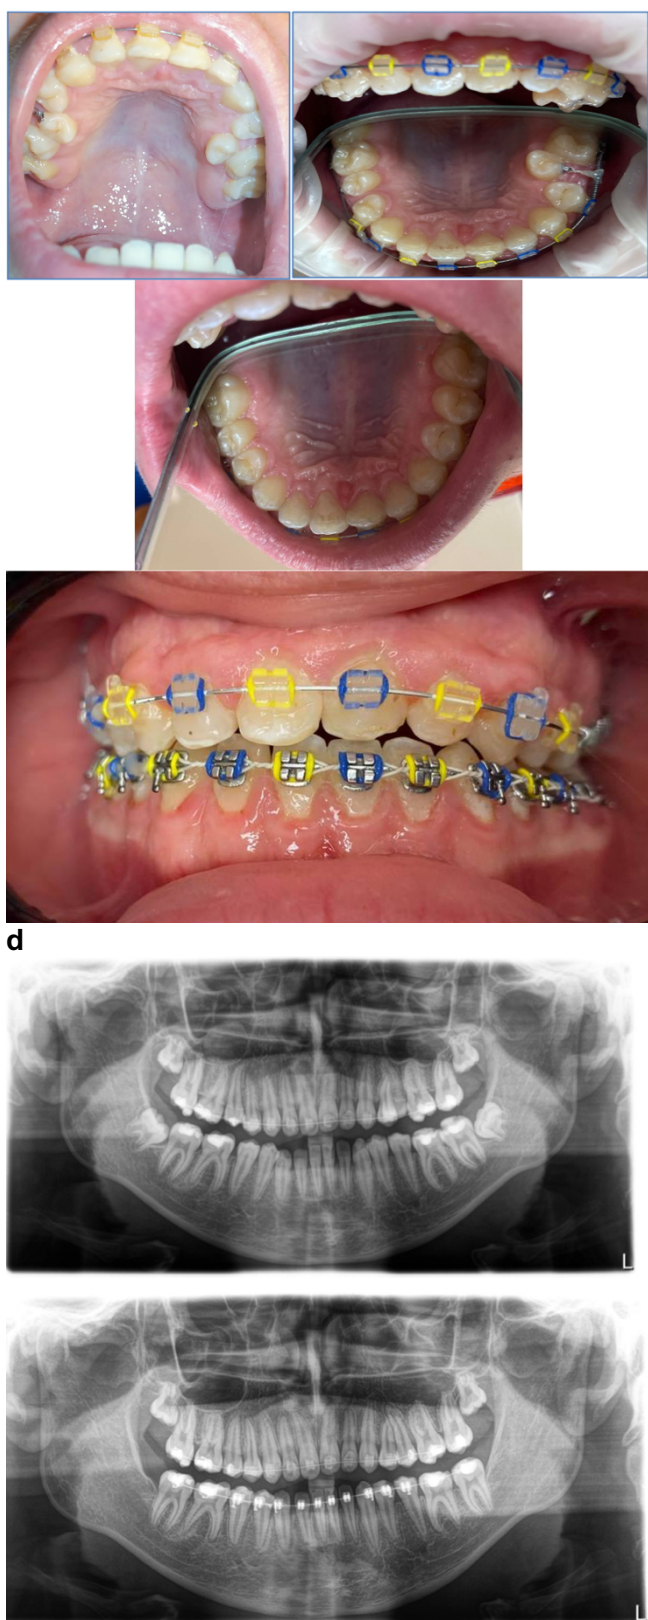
Patient D. (1) orthopantomogram before treatment, (2) 3D computed tomography, impaction of teeth 15 and 25 is visible, (3) - surgical exposure of crowns of palatally impacted
